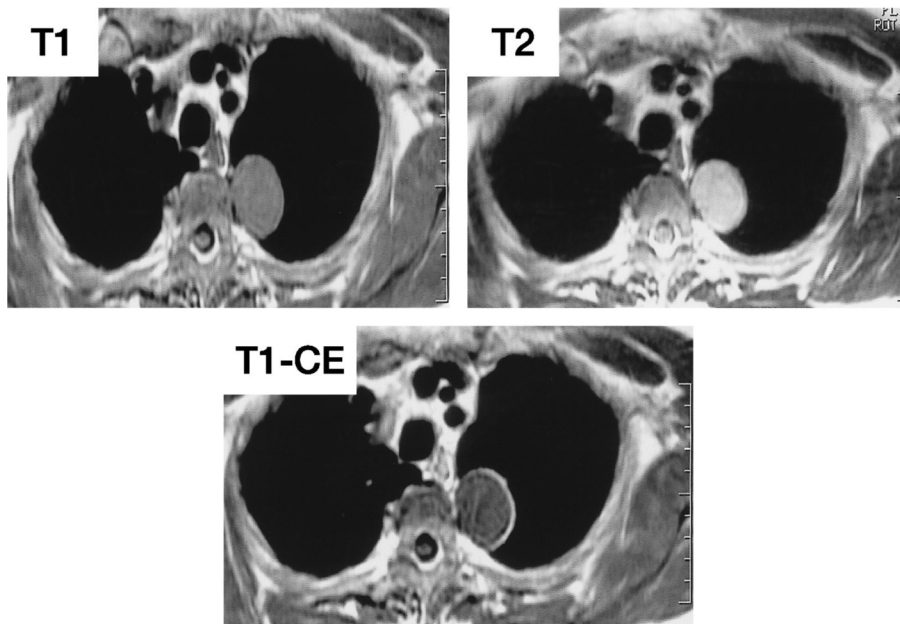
On MRI, the mass was hypointense in T1-weighting and hyperintense in T2-weighting. The contrast pattern was the same as that seen on the CT scan.
